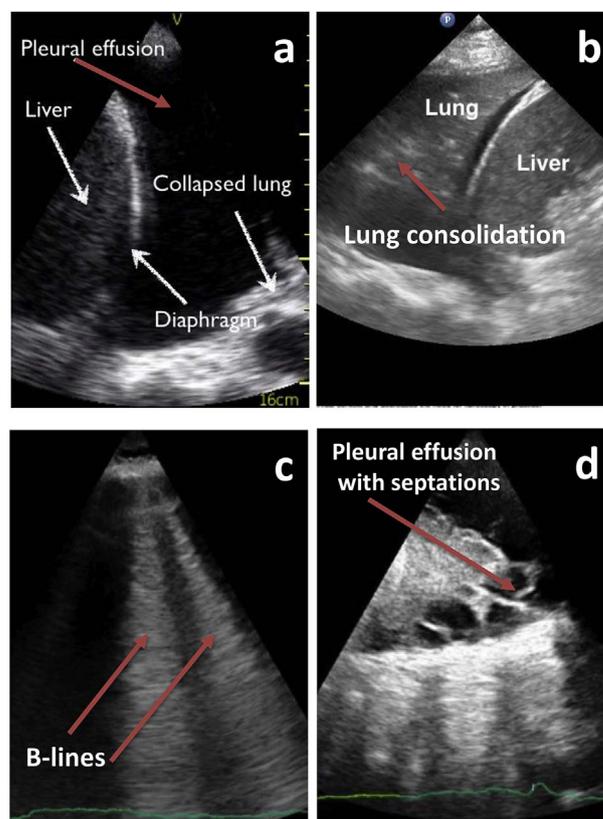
Lung Ultrasound. a-pleural effusion; b-lung consolidation; c- B-lines; d-complex pleural effusion with septations suggestive for empyema.
